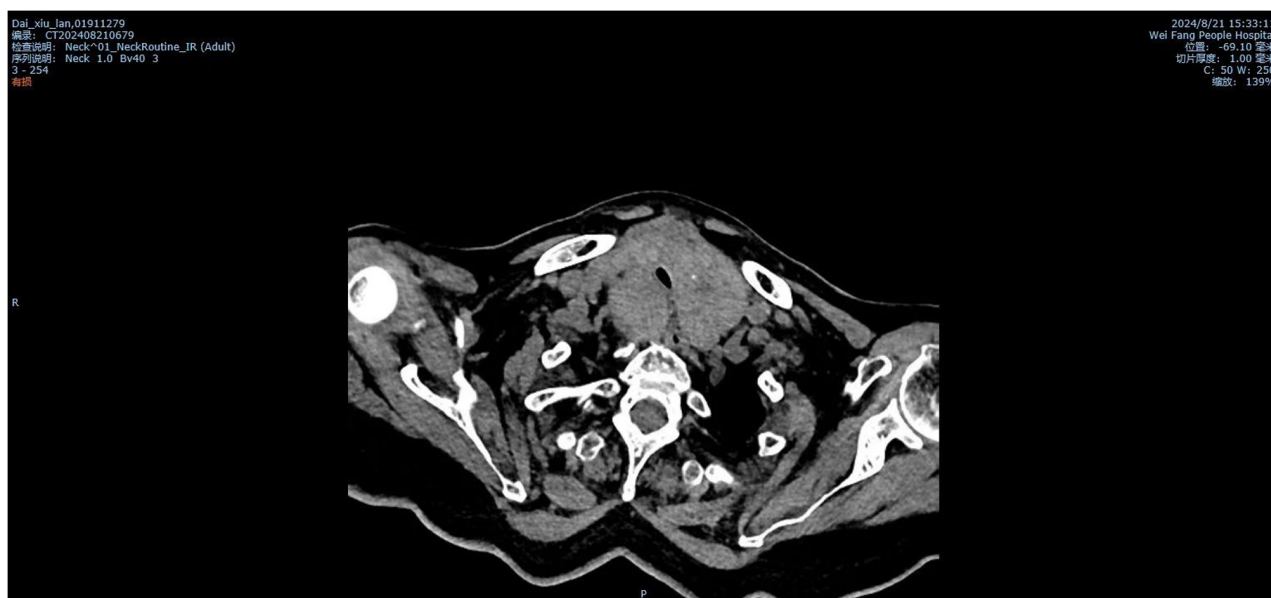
CT scan demonstrating tracheal compression due to the large thyroid. Tracheal lumen diameter was compressed (4.6 mm) prior to surgery.
